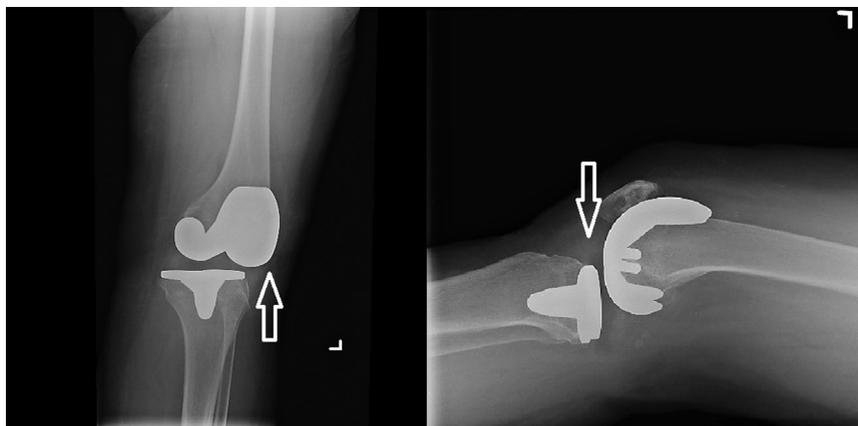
Plain radiographs (anteroposterior and lateral views) of the knee demonstrating malalignment of the femoral component that is posteriorly and laterally subluxed relative to the femoral component.
